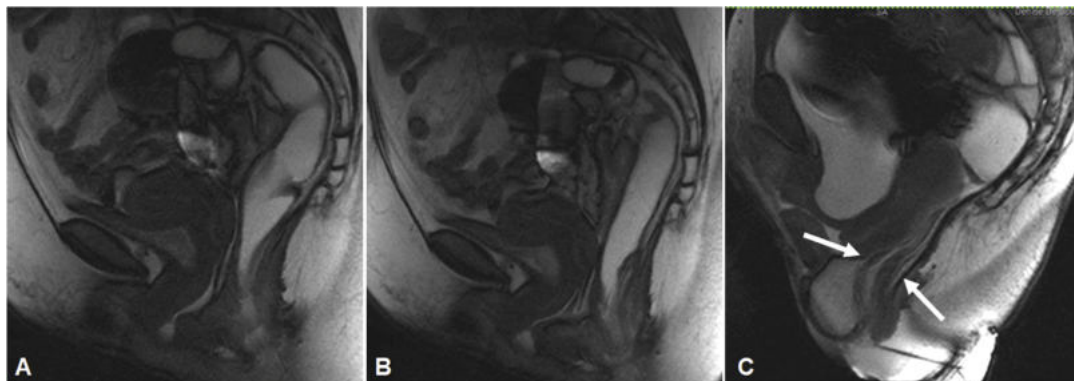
Intussusception. Sagittal MRI T2WI images in the three phases of evacuation shows invagination of the wall of the rectum through the rectum, involving the mucosal layer, compatible with intrarectal invagination. Intussusception is accentuated in the third phase of evacuation (white arrows), showing the importance of repeating this maneuver during defecography. There is anterior rectocele associated.
